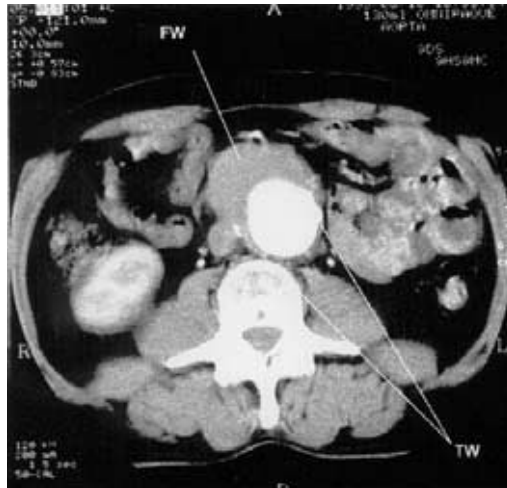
CT scan showing aneurysmal native aorta with calcification in its true posterior wall (TW) and additional thrombotic material anteriorly (FW).
